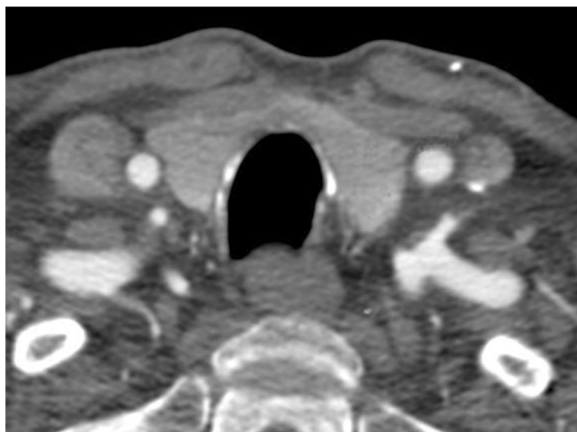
Post-contrast-computed tomography image. Axial view showing a homogeneously enhancing thyroid gland
